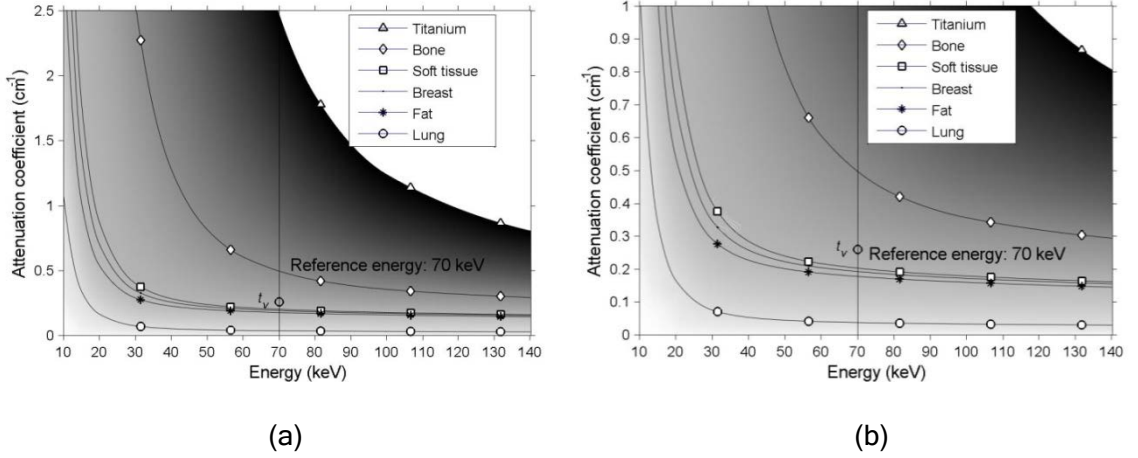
The attenuation coefficient curves [46] of the base materials for chest CT exam. (a) A plot with large attenuation coefficient range [0.0, 2.5] to facilitate the appreciation of the relative relationship between the high attenuation curves and the low attenuation curves. (b) A plot with small attenuation coefficient range [0.0, 1.0] to facilitate the appreciation of the relative relationship of the low attenuation curves. The gray gradient indicates the interpolated attenuation curves along the 70 keV reference energy line.
